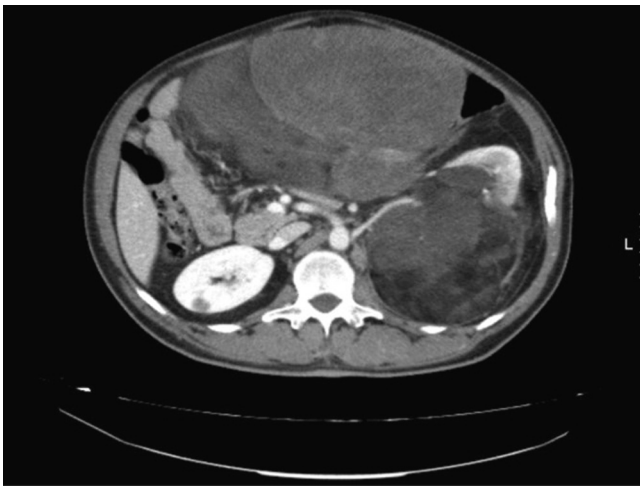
Computed tomography revealed an intraabdominal mass.
